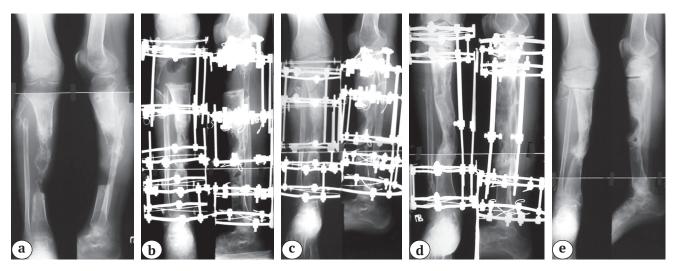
Radiographs of the right tibia in two projections with adjacent joints of the patient S.: a — on admission;
